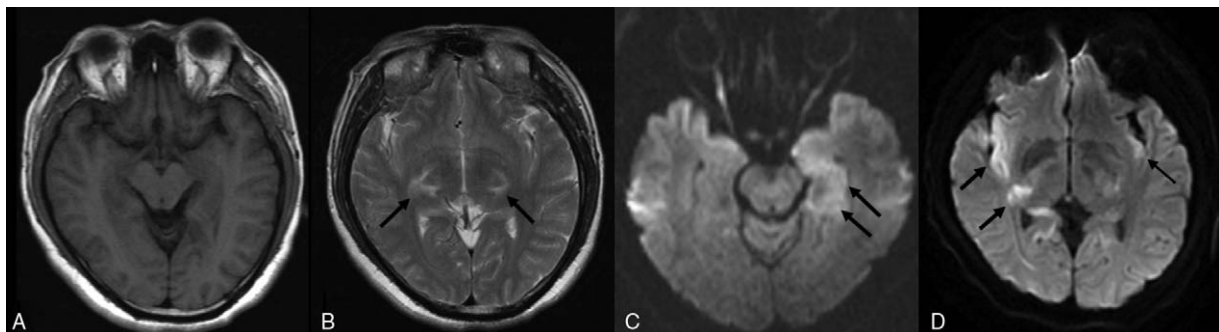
Brain MRIs performed on May 15. (a–d) MRI showed abnormal signals (where the arrow points to) in the right optic-radiation of lateral thalamus, bilateral medial temporal lobes and the insular lobes. a. T1 weighted sequence. b. T2 weighted sequence. c–d. Diffused weighted sequence. MRI=magnetic resonance imaging.
